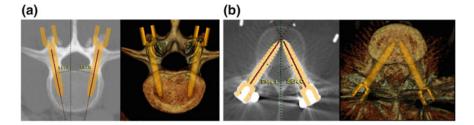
Example of virtual templating and volume render representation at one vertebral segment. a Templating of pre-operative CT scan; b "reverse templating" of post-operative CT (high intensity metal implants are visible in the image)
